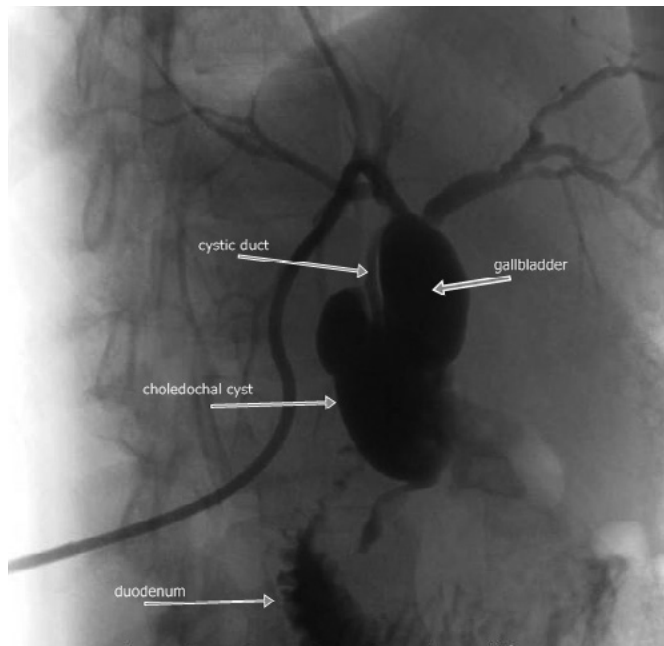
Ultrasound-guided, contrast-enhanced transhepatic cholangiographic images were obtained. The right and left main hepatic ducts were dilated. Cystic dilatation of the proximal choledochal duct and transition of contrast media to the intestine were observed.
